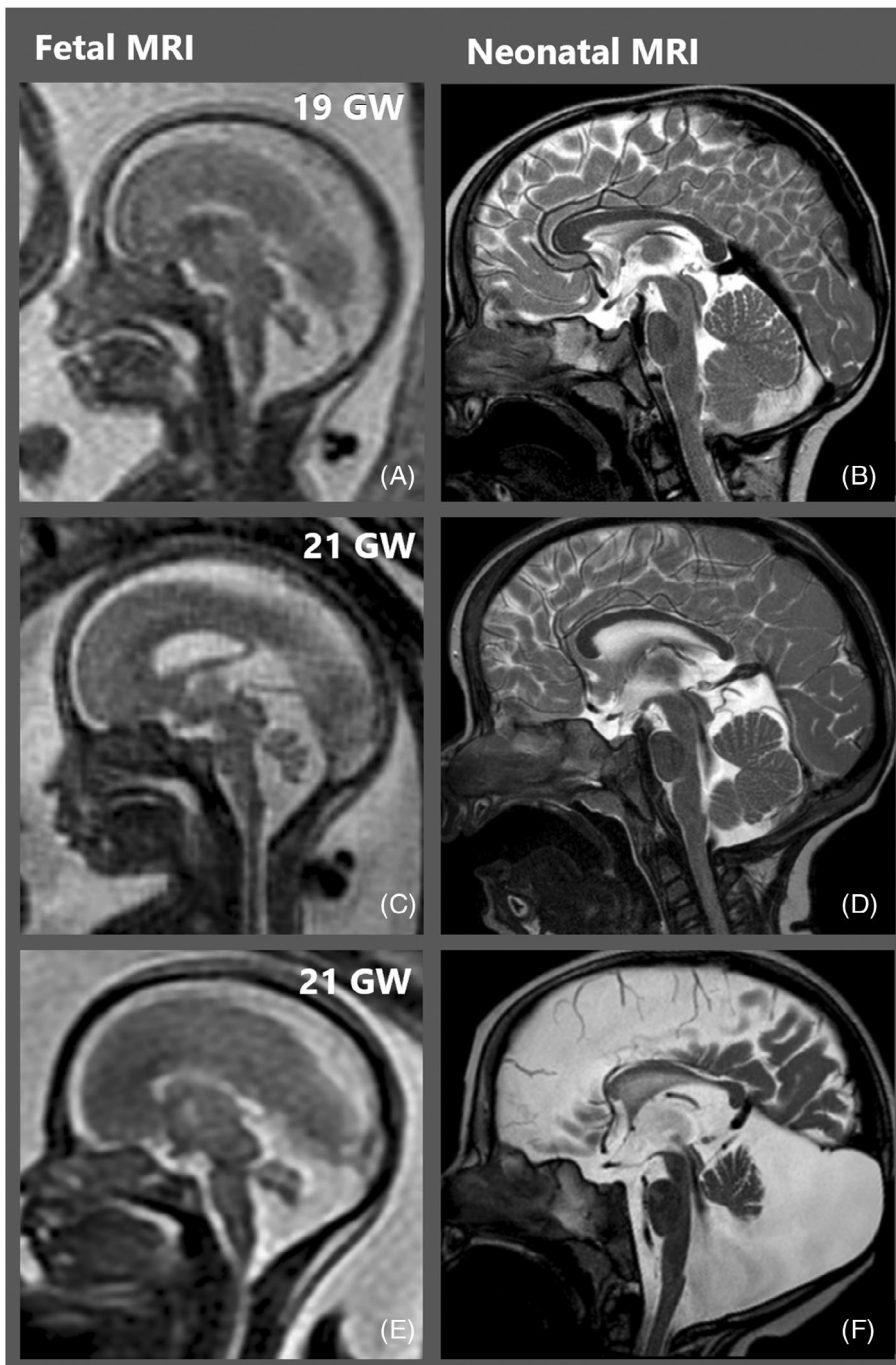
Corresponding images of fetal and postnatal MRI in three patients with vermian rotation. All fetal sagittal T2-weighted MR images (A, C, E) were obtained at 19–21 GW and show similar features, consisting of incomplete rotation of the vermis and wide communication between the fourth ventricle and the cisterna magna. Patient 1 (A, B) is demonstrative of delayed vermian rotation with normal postnatal exam; Patient 2 (C, D) is consistent with a persistence of the Blake's pouch with ensuing vermian hypoplasia; Patient 3 (E, F) demonstrates evolution into a full-blown Dandy-Walker malformation, with progressive enlargement of the posterior fossa and counter-clockwise rotation of the hypoplastic vermis
